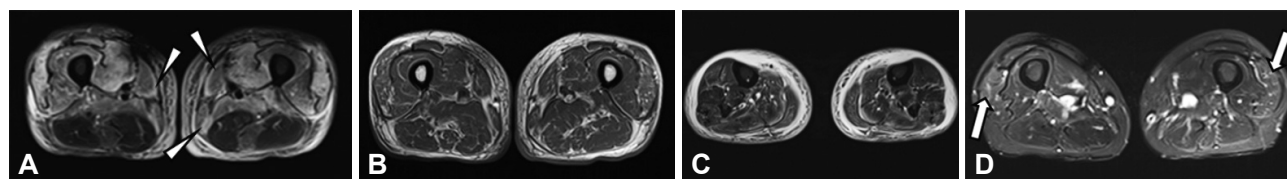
Lower limb skeletal muscle MRI of telbivudine-induced myopathy. A–D: Case 5 showed diffuse increases in signal intensities in the anterior compartments of thigh muscles (A) and fascia (arrowheads) and, to a lesser extent, in the calf muscles (C) on T2-weighted STIR images, with mottled intramuscular and intermuscular hyperintensity of the affected muscles on T1-weighted images (B). Case 2 showed mild hyperintensities in the bi-lateral lateral head of quadriceps femoris on T2-weighted STIR image (D, arrows). STIR, short tau inversion recovery.
